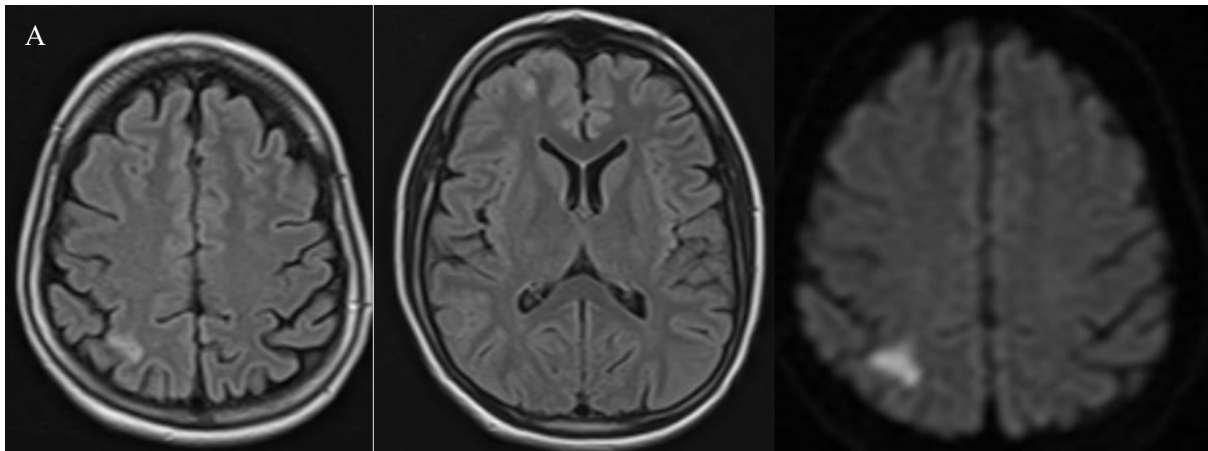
MRI Brain axial views FLAIR T2 & DWI (a,b,c) Acute Right frontal and parietal lobe watershed infarcts involving white matter suggesting acute ischemia.
